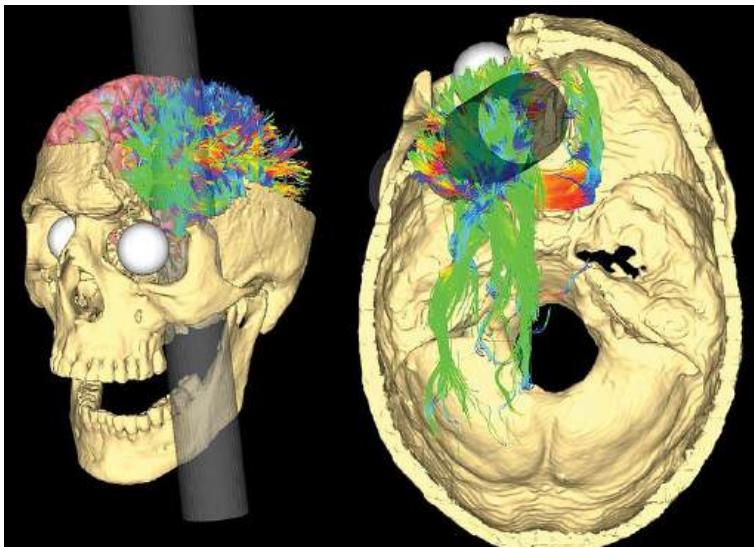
A computerized tomography (CT) image reconstruction of the path of the tamping rod that entered Phineas Gage's mouth and blasted through his skull and left frontal lobe. The bright colors represent White Matter fiber pathways likely intersected by the rod (Van Horn et al. 2012).
